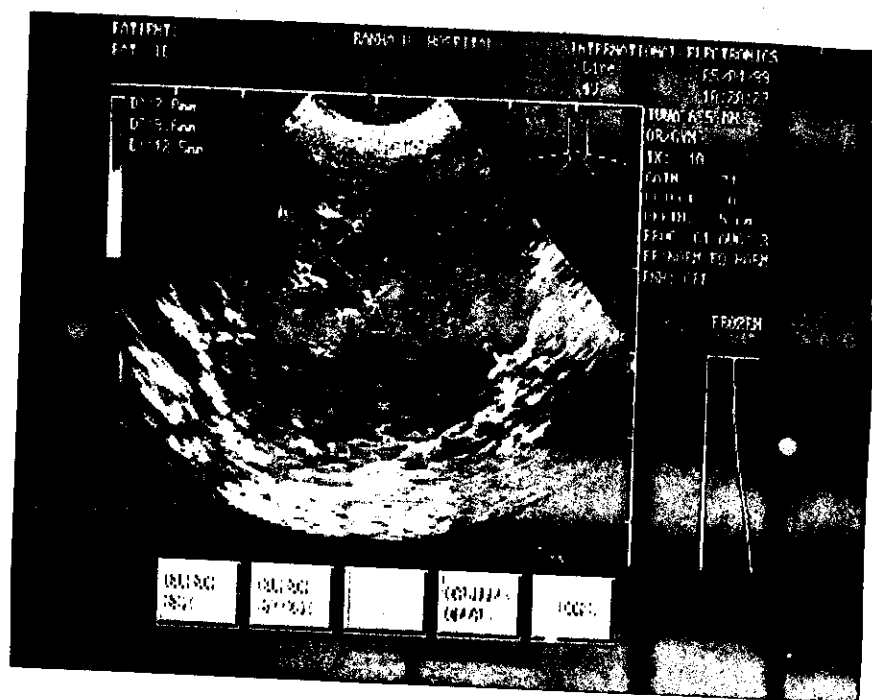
Shows a sonographic picture of endometrial polyp.
